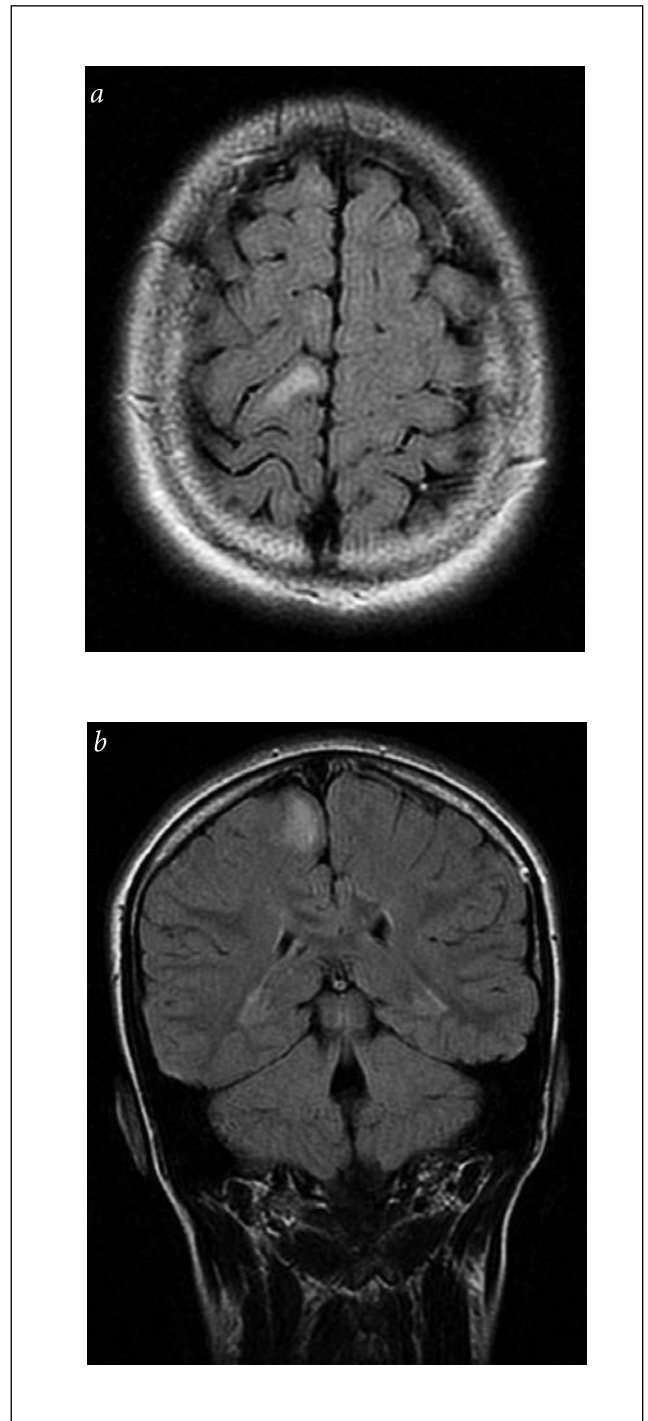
A 13-year-old girl with headaches, without neurological signs and symptoms. The girl's father died of brain tumour (unknown pathological diagnosis) at the age of 27. MRI, FLAIR sequence in axial (a) and coronal (b) planes shows a hyperintense, subcortical lesion widening the cortical gyrus. MRI is suggestive of highly differentiated glioma.
